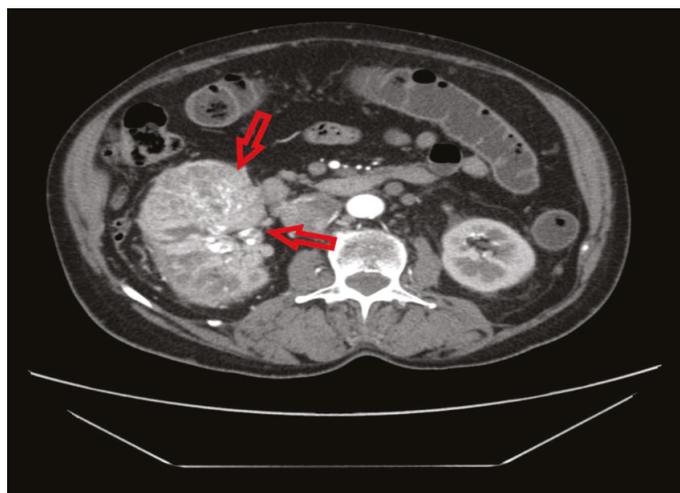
Abdominal CT with contrast, cross-section – right kidney tumor (arrows).
